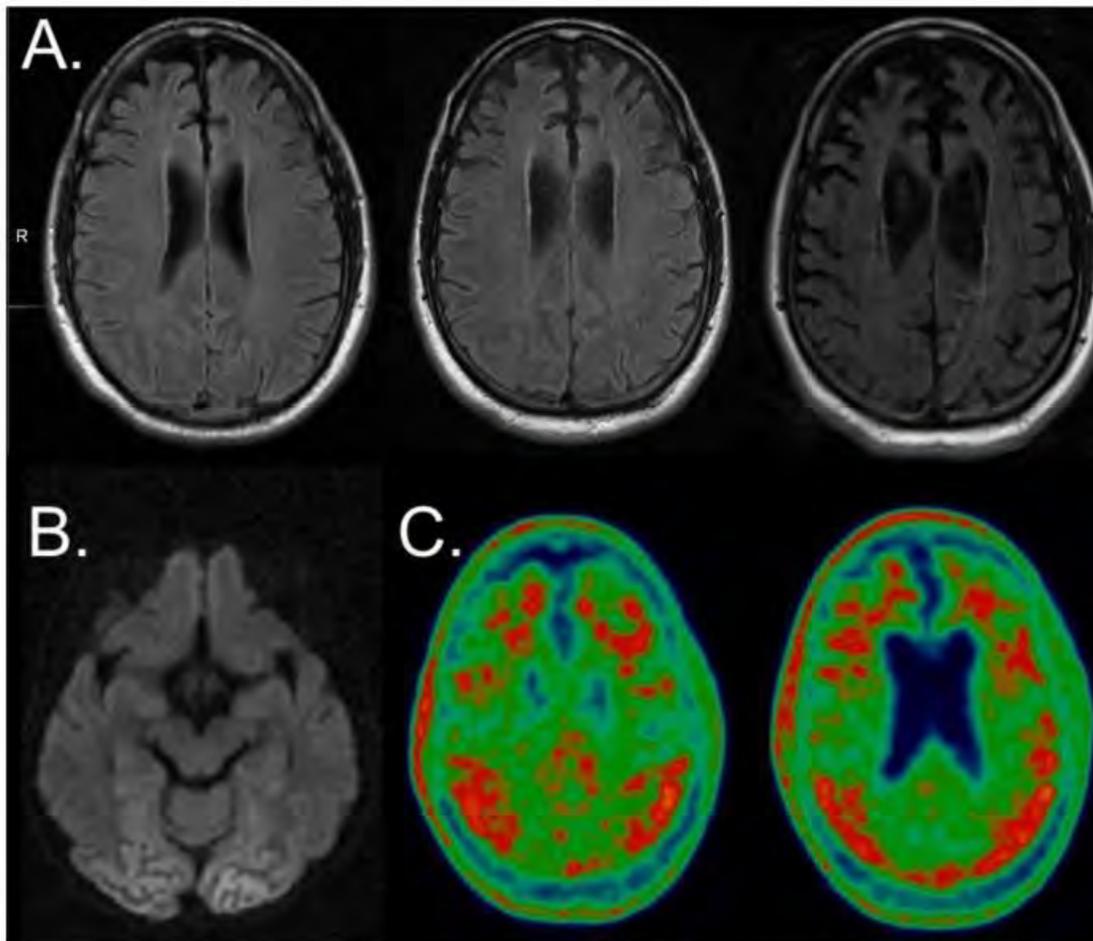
Neuroimaging findings in vacuolar tauopathy. A. FLAIR images from three studies, each 2 years apart (earliest on the left) showing progressive frontal atrophy. B. Diffusion-weighted imaging shows posterior cortical diffusion restriction. C. ¹⁸F-flortaucipir PET shows tracer binding.
